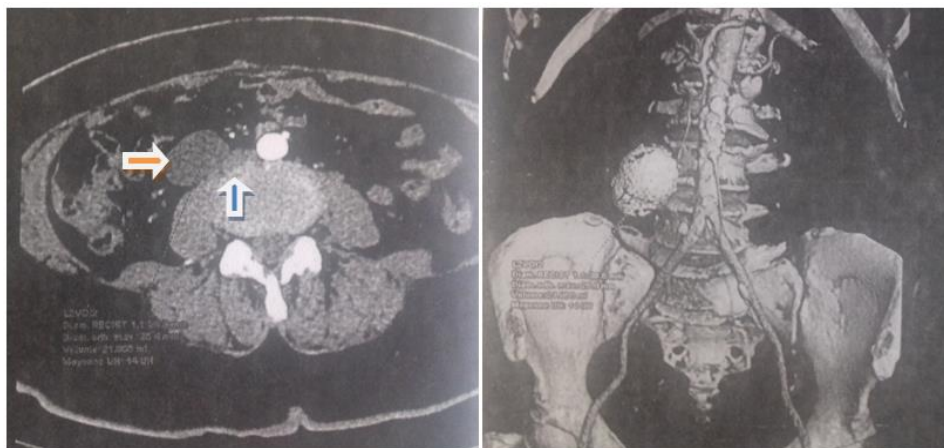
Axial CT scan: cystic lymphangioma (orange arrow) which compresses the vci (blue arrow)
